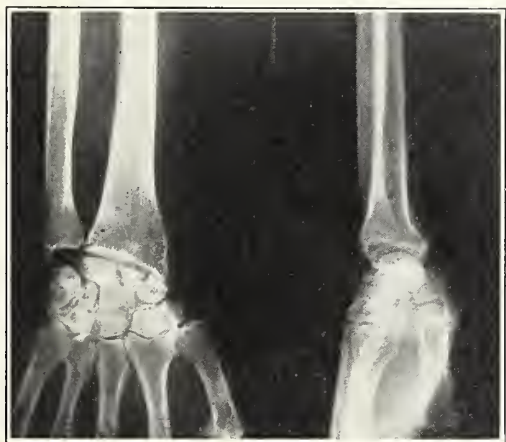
Roentgenogram showing areas of rarefaction in the semilunar, os magnum, and scaphoid, plus an old fracture of the scaphoid.
